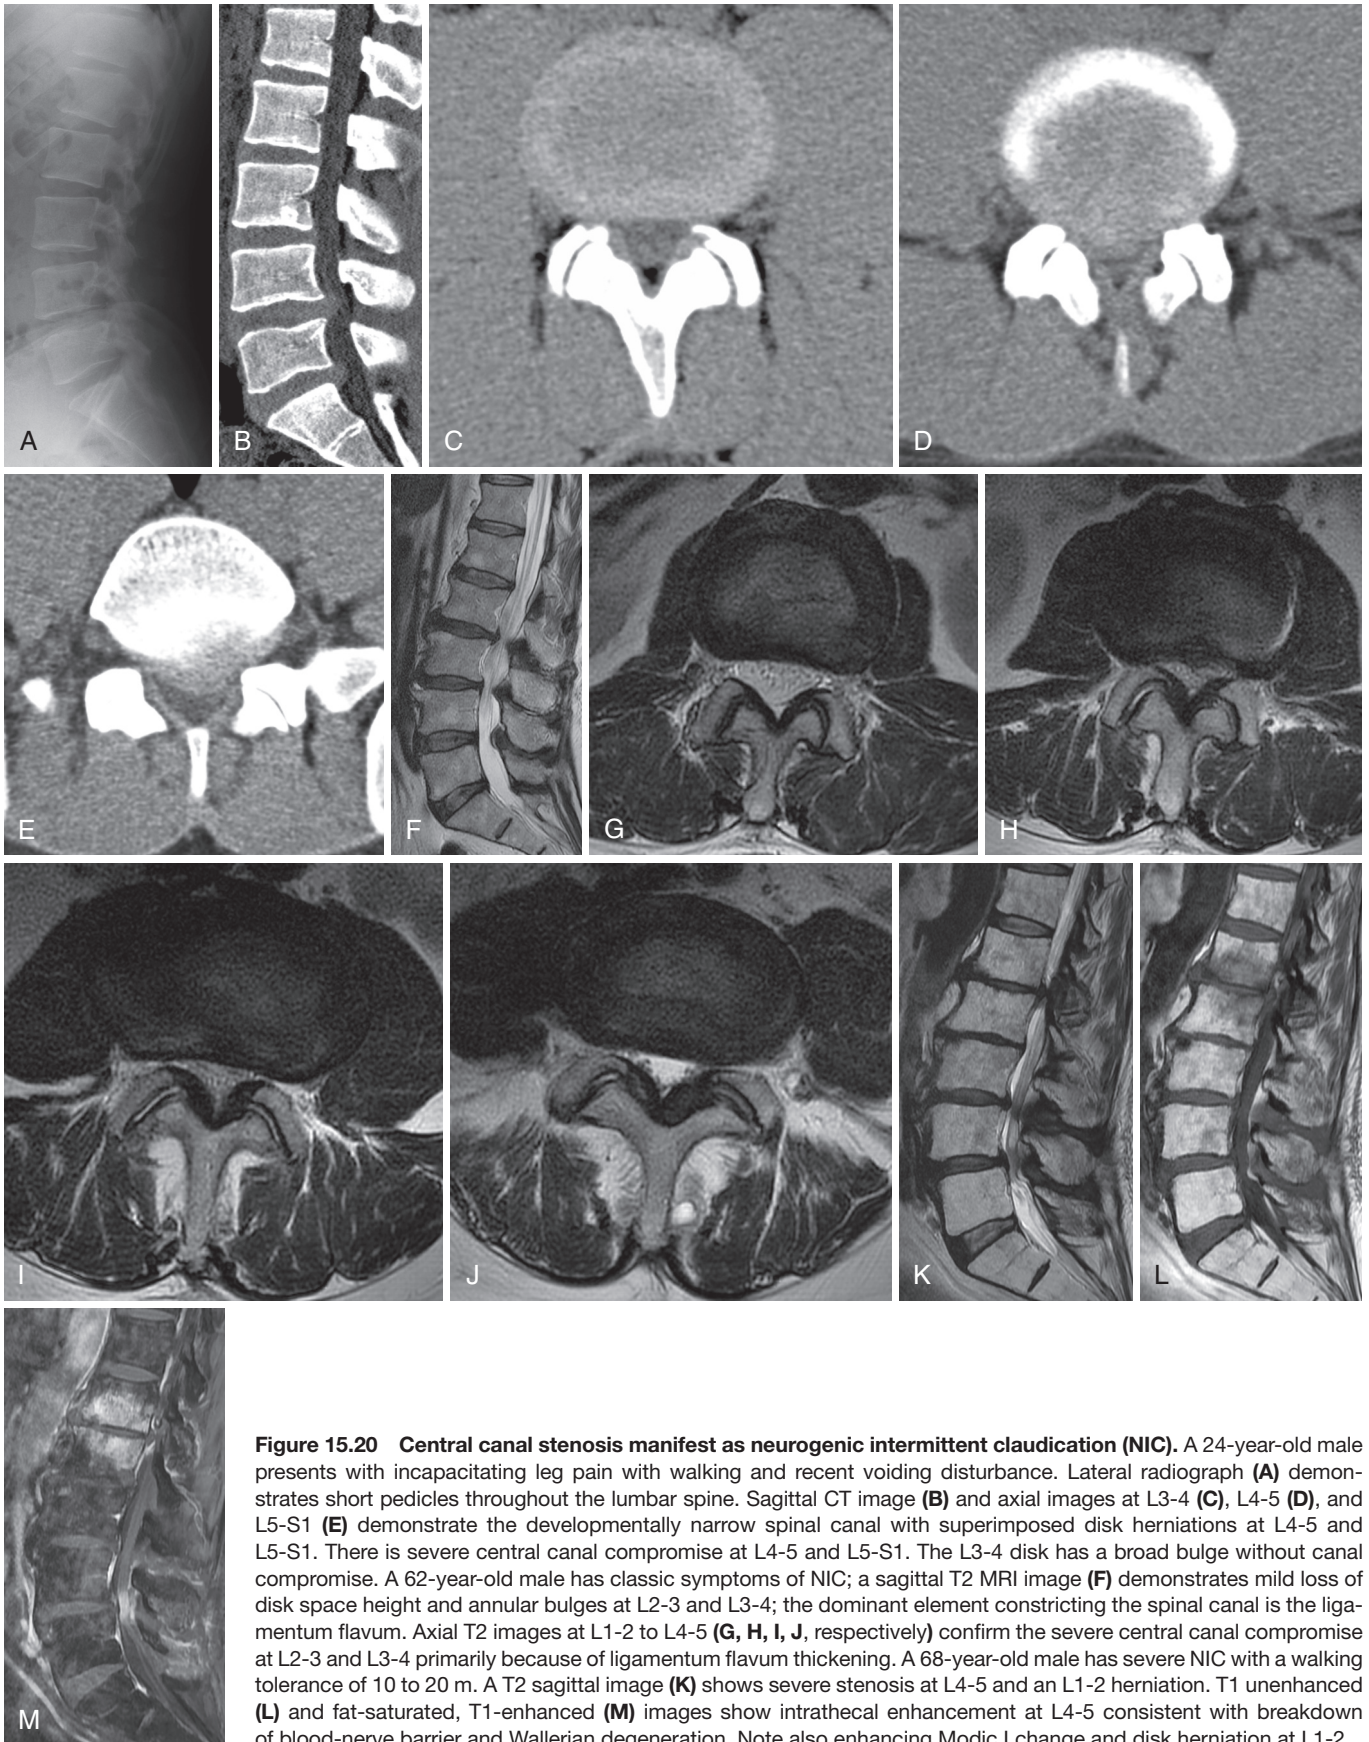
Central canal stenosis manifest as neurogenic intermittent claudication (NIC). A 24-year-old male presents with incapacitating leg pain with walking and recent voiding disturbance. Lateral radiograph (A) demonstrates short pedicles throughout the lumbar spine. Sagittal CT image (B) and axial images at L3-4 (C), L4-5 (D), and L5-S1 (E) demonstrate the developmentally narrow spinal canal with superimposed disk herniations at L4-5 and L5-S1. There is severe central canal compromise at L4-5 and L5-S1. The L3-4 disk has a broad bulge without canal compromise. A 62-year-old male has classic symptoms of NIC; a sagittal T2 MRI image (F) demonstrates mild loss of disk space height and annular bulges at L2-3 and L3-4; the dominant element constricting the spinal canal is the ligamentum flavum. Axial T2 images at L1-2 to L4-5 (G, H, I, J, respectively) confirm the severe central canal compromise at L2-3 and L3-4 primarily because of ligamentum flavum thickening. A 68-year-old male has severe NIC with a walking tolerance of 10 to 20 m. A T2 sagittal image (K) shows severe stenosis at L4-5 and an L1-2 herniation. T1 unenhanced (L) and fat-saturated, T1-enhanced (M) images show intrathecal enhancement at L4-5 consistent with breakdown of blood-nerve barrier and Wallerian degeneration. Note also enhancing Modic I change and disk herniation at L1-2.
